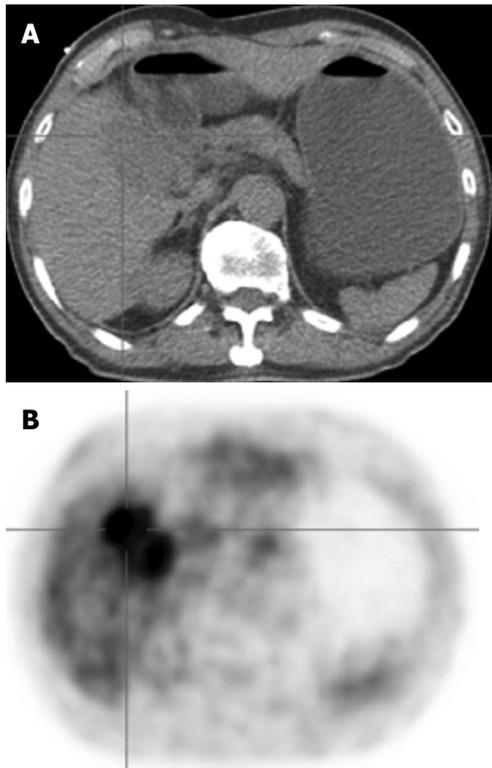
A case of cholangiocellular carcinoma. A: Non-contrast computed tomography (CT) obtained by PET/CT (low-dose CT); B: FDG-PET. Cholangiocellular carcinoma is usually depicted as an FDG-avid tumor unlike hepatocellular carcinoma.
